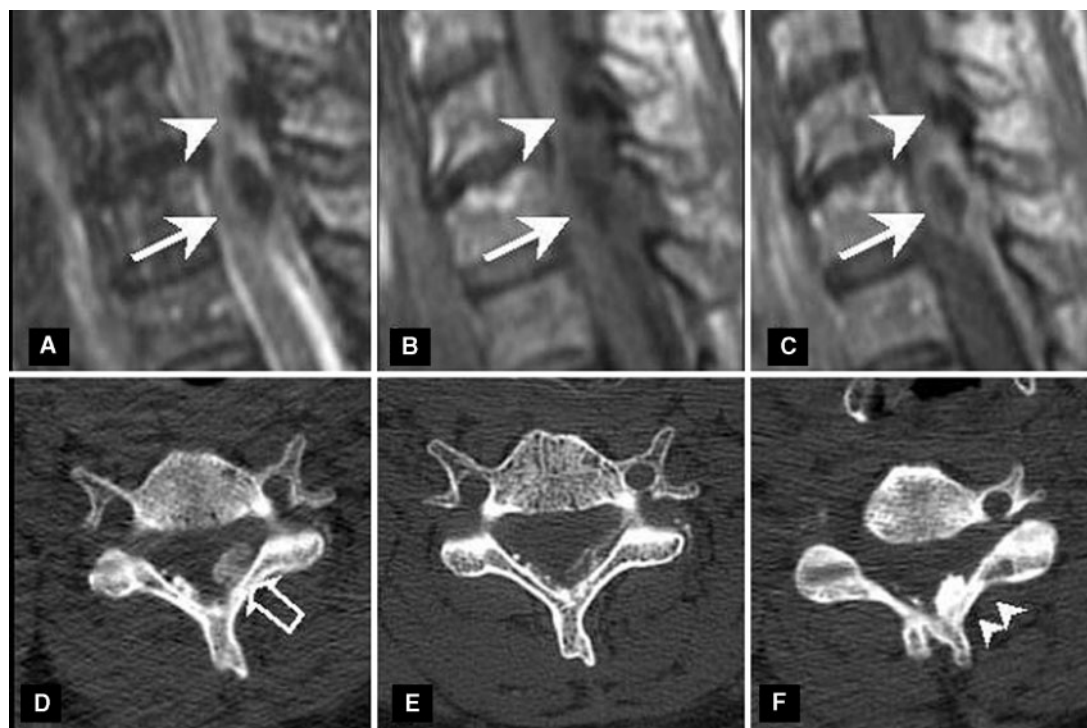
Imaging of the cervical spine. MRI (A, B, C) made during the acute clinical stage (day 3). Sagittal T2-weighted image (A) and T1-weighted image before (B) and after (C) administration of gadolinium. It shows two calcifications inside the ligamentum flavum. The C7 calcification (arrow) in state of resorption has an inflammatory rim that is hyper-intense on T2-weighted imaging and hypo-intense on T1-weighted images and that shows contrast enhancement. The C6 ligamentum flavum calcification (arrow head) has no inflammatory aspect on MRI. A 3D CT scan in axial view (D, E, F). During the acute clinical stage (day 3) it shows a cloud-like calcification inside the ligamentum flavum at C7 (D: empty arrow), less dense than a second calcification inside the C6 ligamentum flavum (F: double arrow head). Control CT scan at day 10: near complete disappearance of the calcification at C7 (E). There was no change of the C6 calcification.
